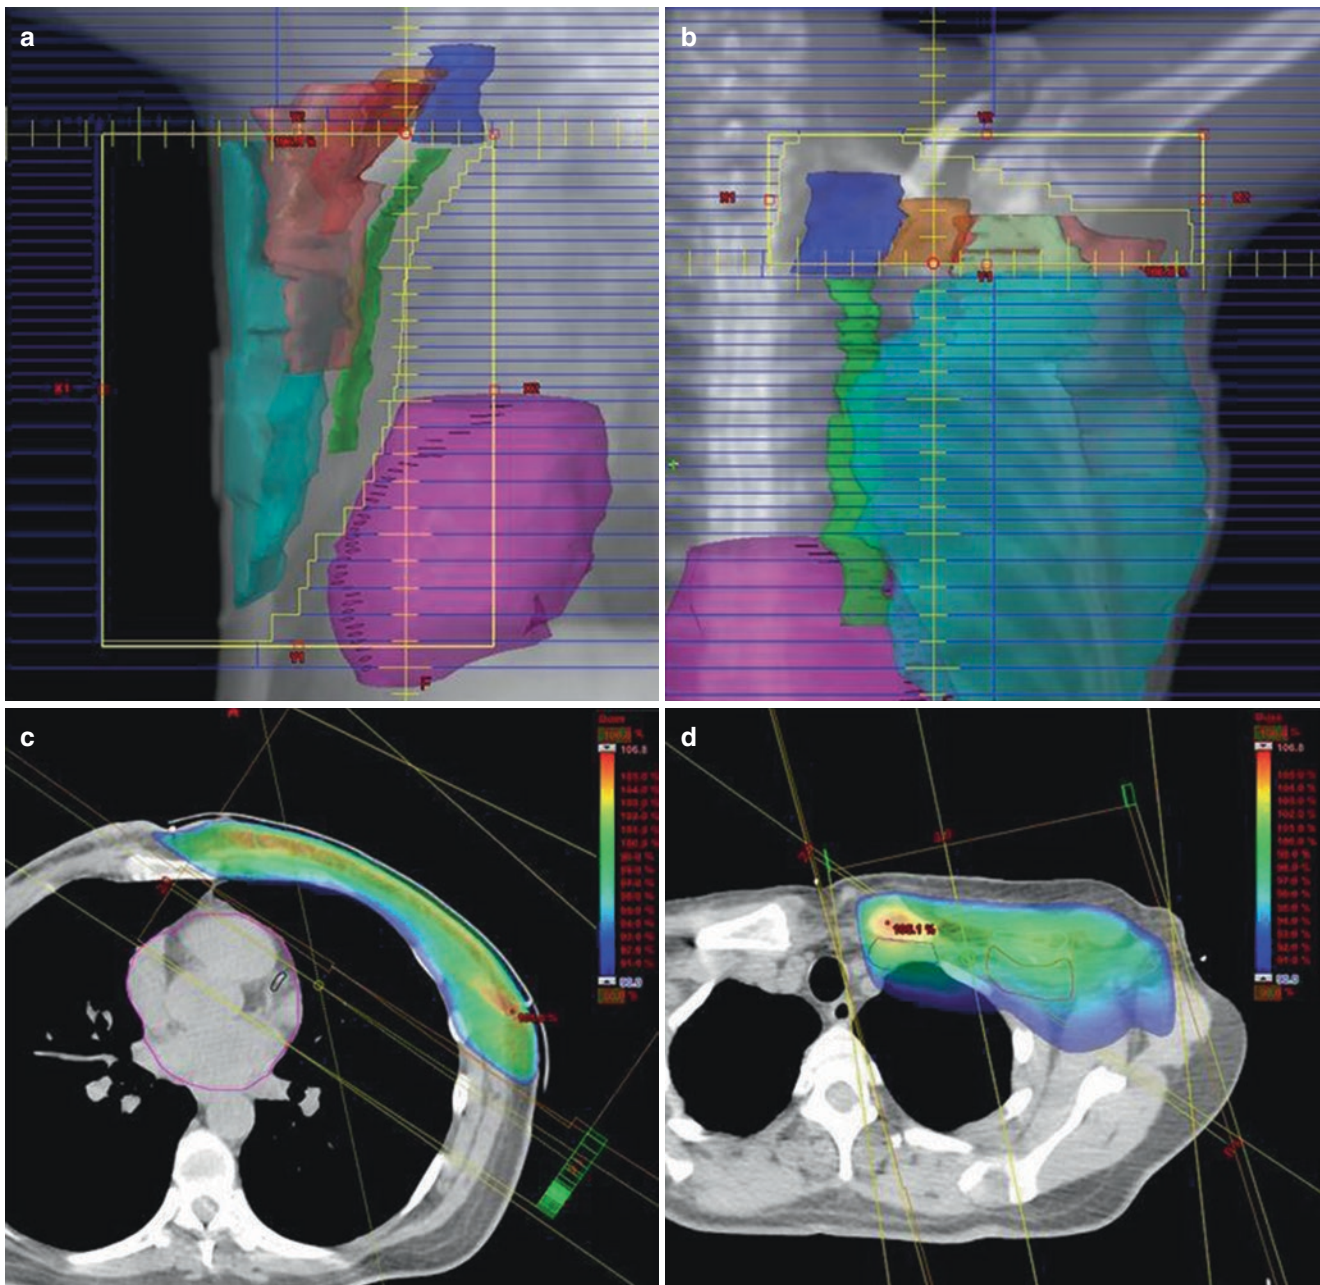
The mono-isocentric PWTF technique with beam's eye view of one of the half-beam tangential fields (a) and the slightly oblique AP half-beam field (b). The transversal CT slices show the dose distribution at the heart level (c) and in the supraclavicular region
